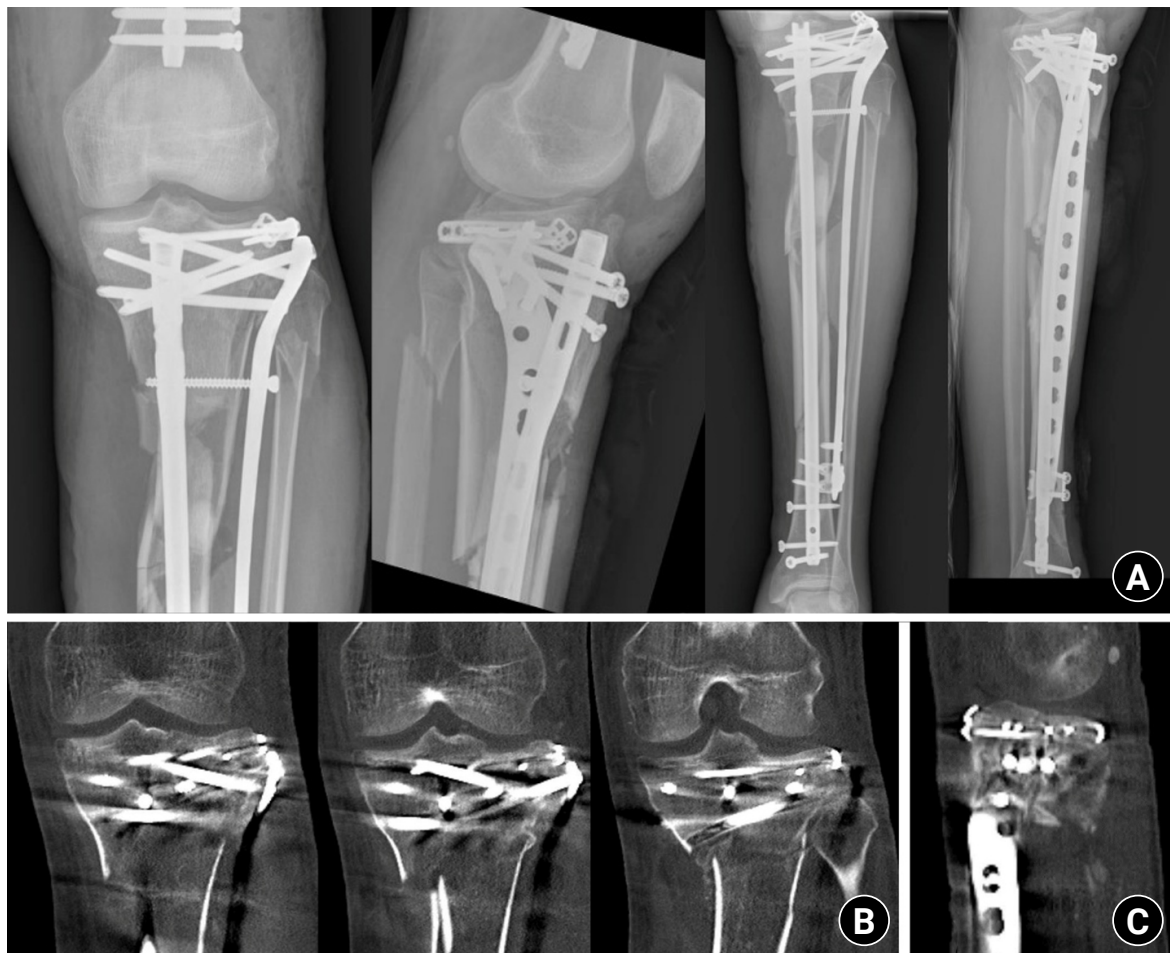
Postoperative plain radiograph and computed tomography (CT) images. (A) Postoperative plain radiograph. (B) Coronal and (C) sagittal CT images after fixation.
